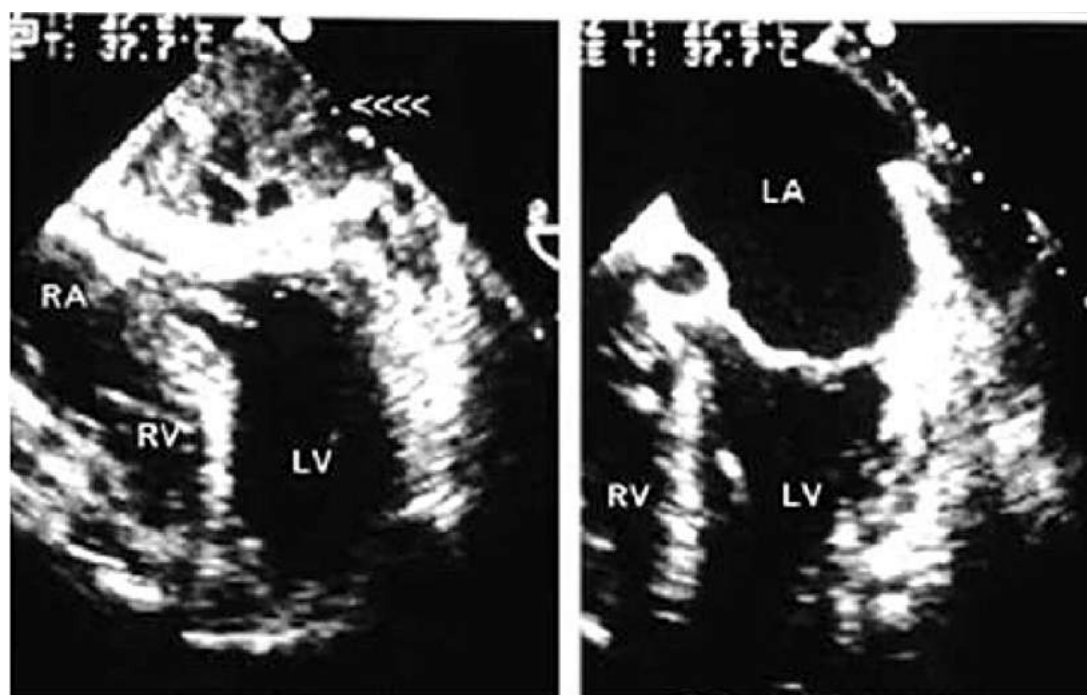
Transoesophageal transversal view of pericardial post-operative clots before and after surgical removal.
